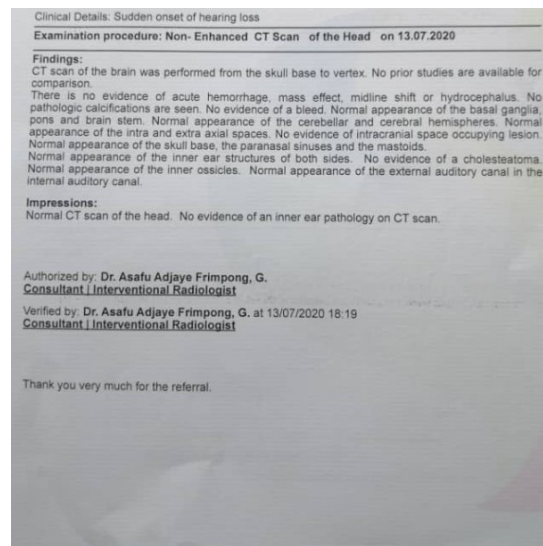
A CT scan of the head showed no pathology.
